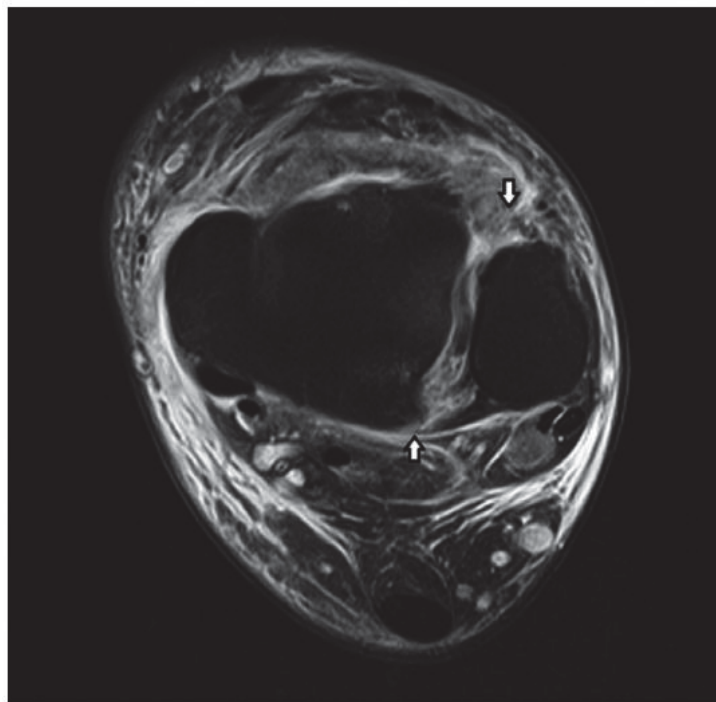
MRI at the syndesmotic level showing injured ligament
